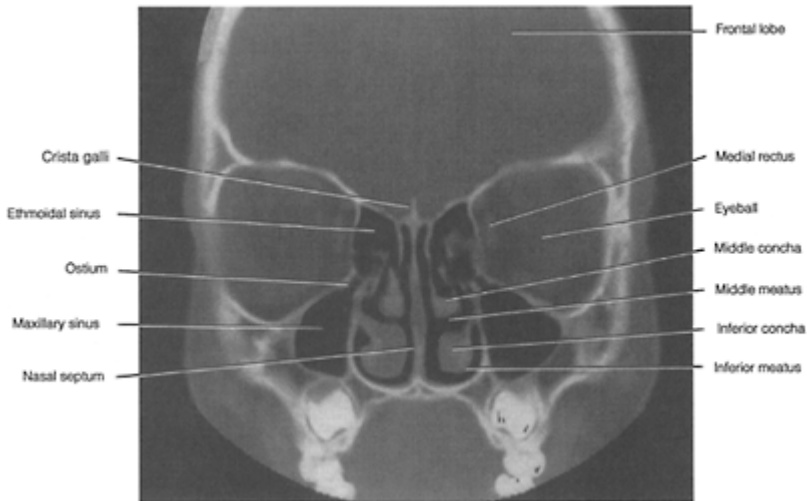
CT scan of normal sinuses, coronal view.
